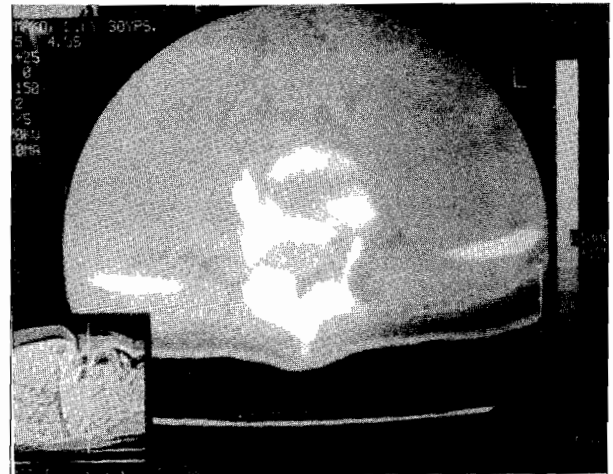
Contrast enhanced axial CT image of the vertebral body showing fragmentary pattern of bone destruction. Note the extradural compression of the spinal cord on the right.
